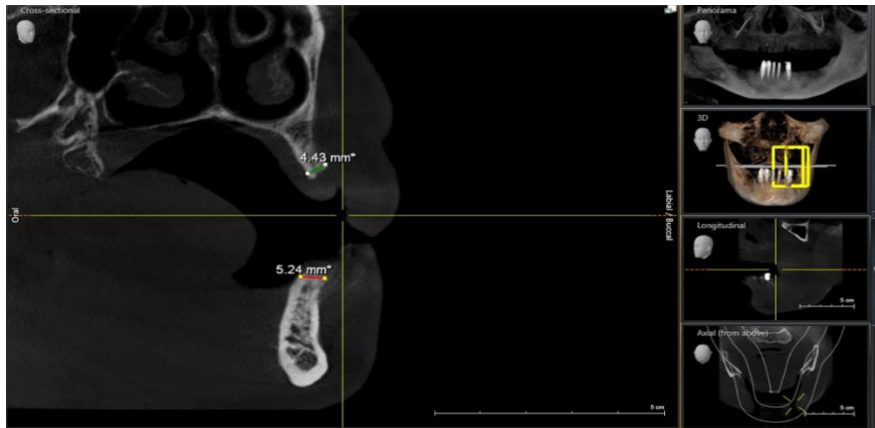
preoperative Cone Beam CT Scan showing the bone thickness on 14 and 44.
